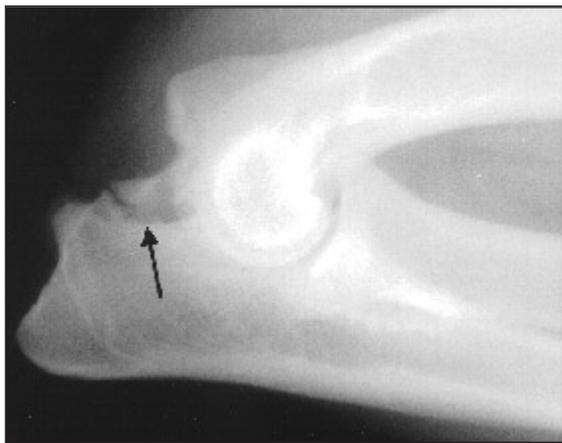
Extreme flexed lateral radiographic projection of the elbow joint. The ununited anconeal process is completely separated from the ulna by the line at the point of the arrow.
